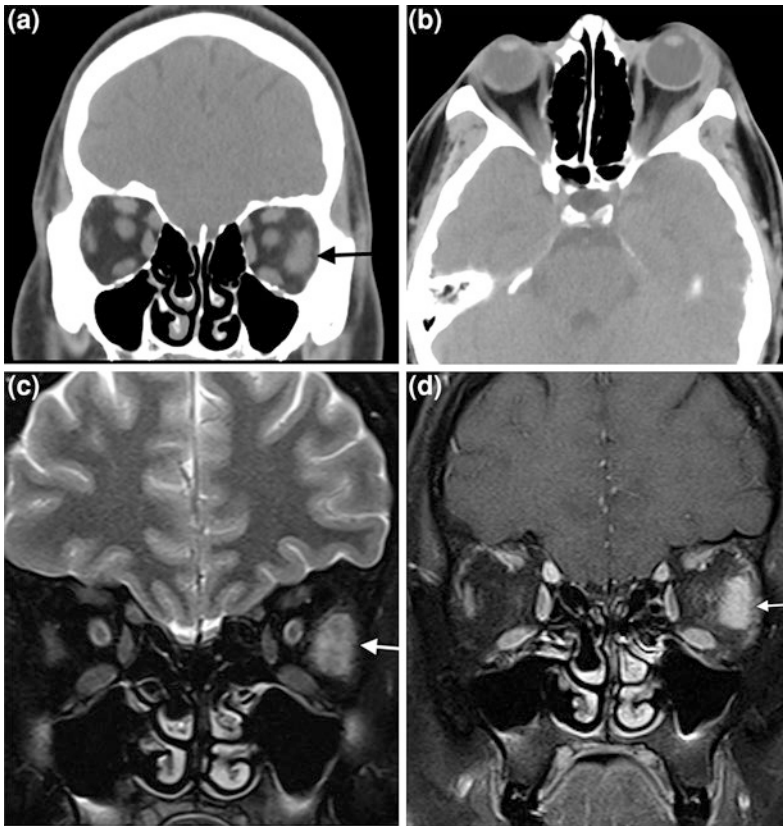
Orbital pseudotumour with enlargement of the lateral rectus muscle. a–b Axial and coronal non-enhanced CT images, c–d Coronal T2WI and contrast-enhanced fat suppression T1WI demonstrate enlargement of the left lateral rectus muscle with stranding of the adjacent fat (arrows)
